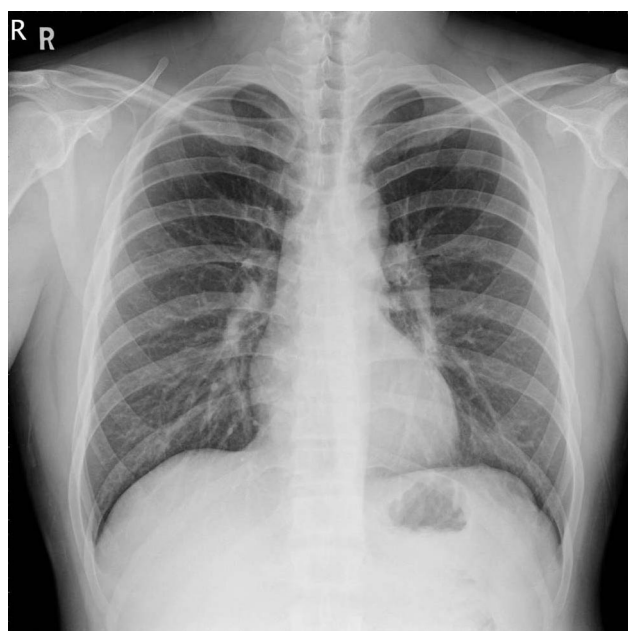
Follow-up chest x-ray 4 days after extraction of the foreign body showed reduced prominence of the left hilum.
